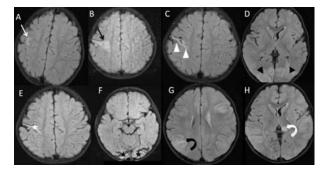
Sequential axial flair MR images of the patient: Baseline MRI *a*) shows the presence of frontal subcortical white matter lesion (white arrow). MRI after 24 days *b*) shows the progression of frontal subcortical white matter lesion (black arrow). Interval MRI after one month, *c*,*d*) shows gliosis in the right frontal subcortical lesion (white arrowheads) and appearance of bilateral occipital subcortical lesions (black arrowheads). Interval MRI after 1.5 months (e,f) shows gliosis in the frontal (white star) and occipital (black stars) subcortical lesions. Interval MRI after five months (g,h) shows the appearance of new parietal subcortical (curved black arrow) and thalamus (curved white arrow) lesions. No evidence of any diffusion-weighted abnormality, susceptibility-weighted abnormality, contrast enhancement, or angiographic abnormality was noted in all the MRI examinations.
